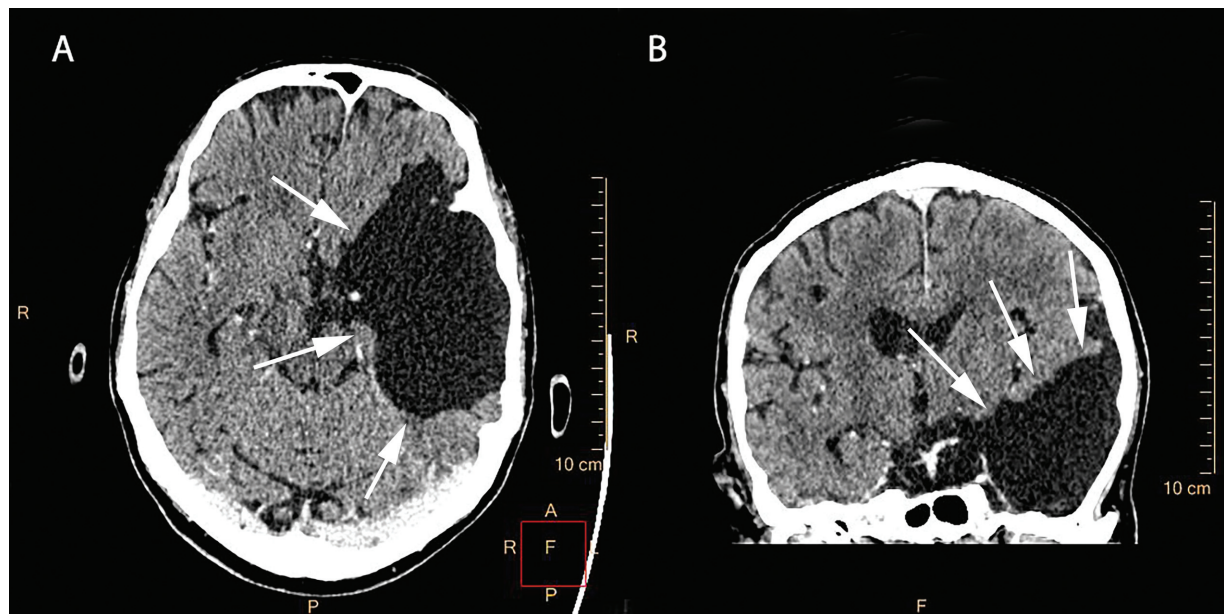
Cranial computed tomography axial (A) and coronal (B) views showing arachnoid cyst (arrows) occupying left frontotemporal region.
